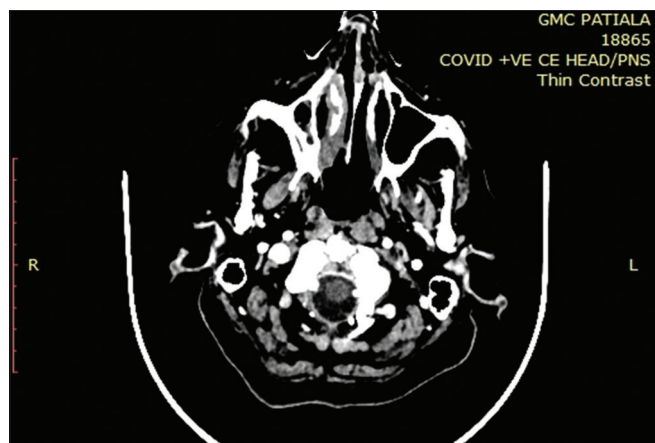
Contrast-enhanced computed tomography paranasal sinuses demonstrates soft-tissue density material partially opacifying right nasal cavity and right maxillary sinus
